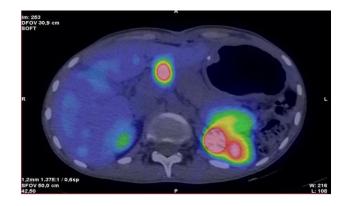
Somatostatin receptor scintigraphy, axial cut.
